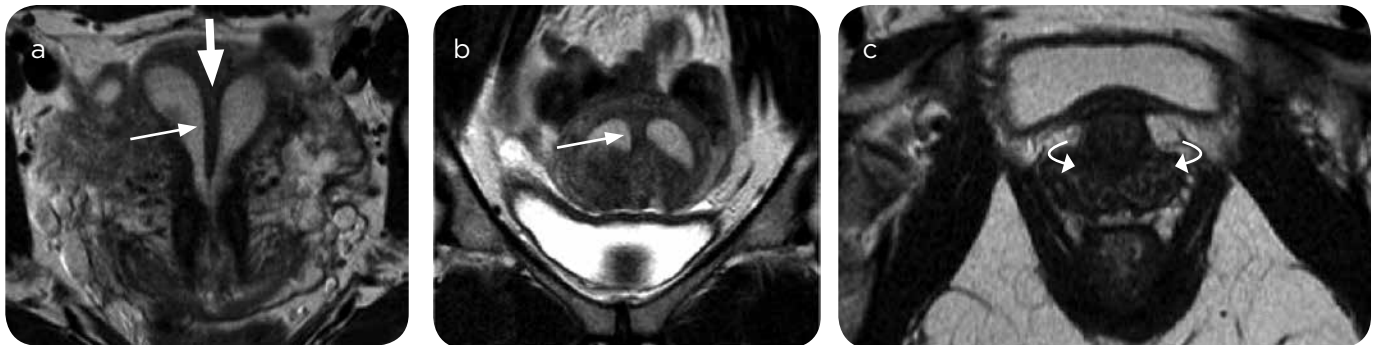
Complete septate uterus. a) Coronal T2-weighted TSE MR, oblique to the major axis of the uterus; b) coronal TSE enhanced in T2; c) axial TSE enhanced in T2. External uterine contour of the convex fundus (thick arrow in a), with intercornual distance less than 4 cm. Complete septum extending from the fundus to the internal cervical orifice (arrow in a and b). Vaginal partition forming two vaginas (curved arrows in c).
